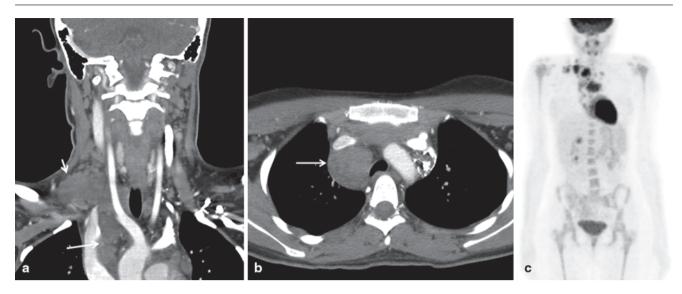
Hodgkin lymphoma (HL). Sixteen-year-old girl with right neck and supraclavicular mass. CT scan (a and b) shows a nodal conglomerate extending from neck into the mediastinum (*arrows*). PET
